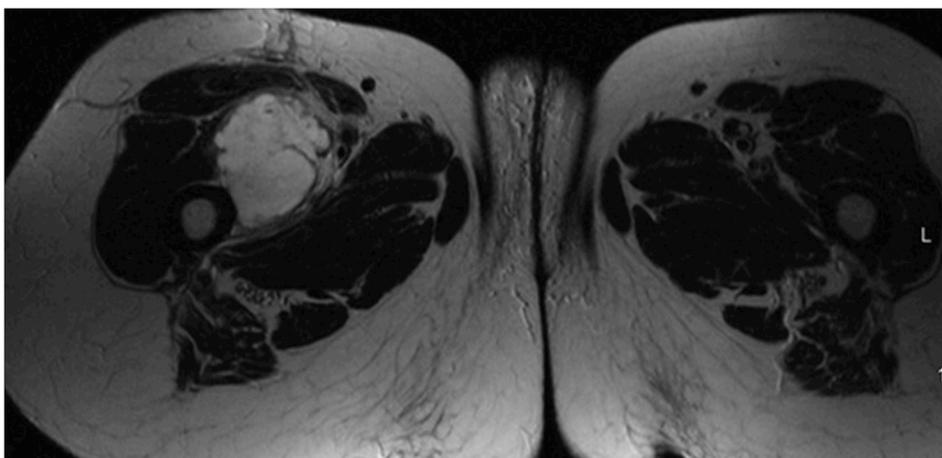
T2-weighted axial image. The lesion is hyperintense compared to adjacent muscle tissue. Multiple septa can be seen within the lesion.
